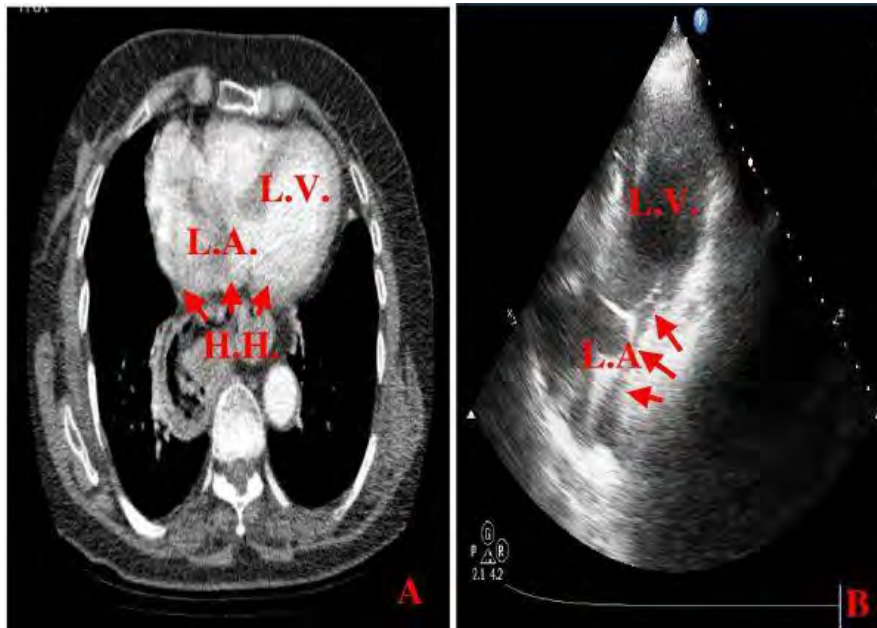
A) Axial computed tomography scan (post contrast) demonstrating well-defined large ovoid-shaped sizable hiatus hernia (83x63x48 mm) impinging on the posterior aspect of the left atrium (arrows). B) Apical four chamber view of transthoracic echocardiography revealing almost complete obliteration of the left atrium by the echolucent apparent mass (arrows). LV; left ventricle, LA; left atrium, HH: Hiatal hernia.
